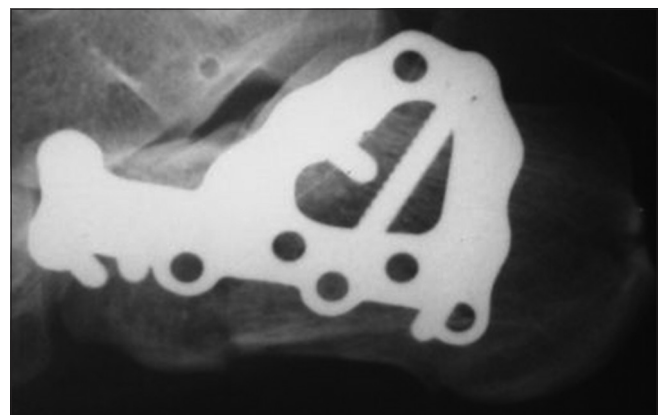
Final post of X-ray
